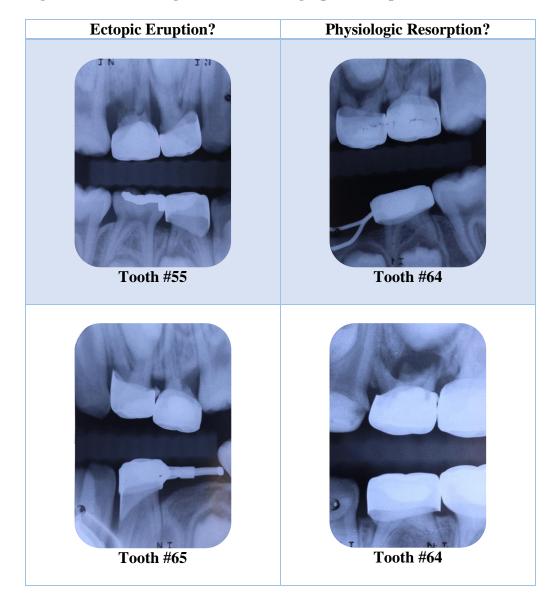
Confounding Factors of Radiographic Interpretation
